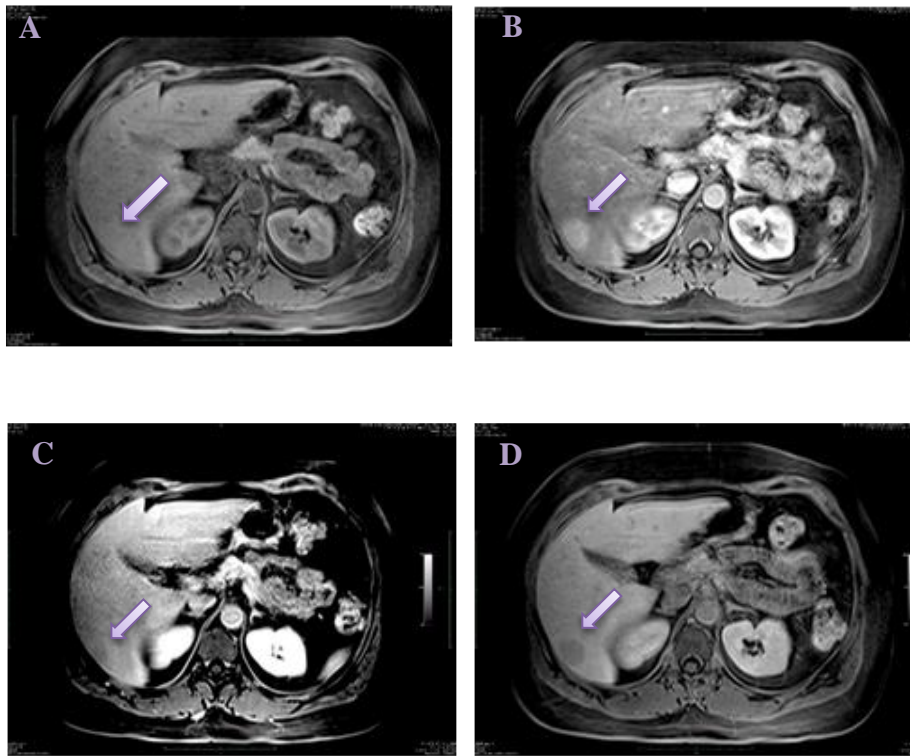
Dynamic MRI study of a IHCA in pre-IVC (A), arterial (B), delayed (C) and hepatospecific (D) phases. The lesion appears almost isointense before contrast injection; the tumor is hypervascular in the arterial phase, and shows washout in the delayed phase. In the hepatospecific phase it becomes hypointense compared to the surrounding parenchyma.
